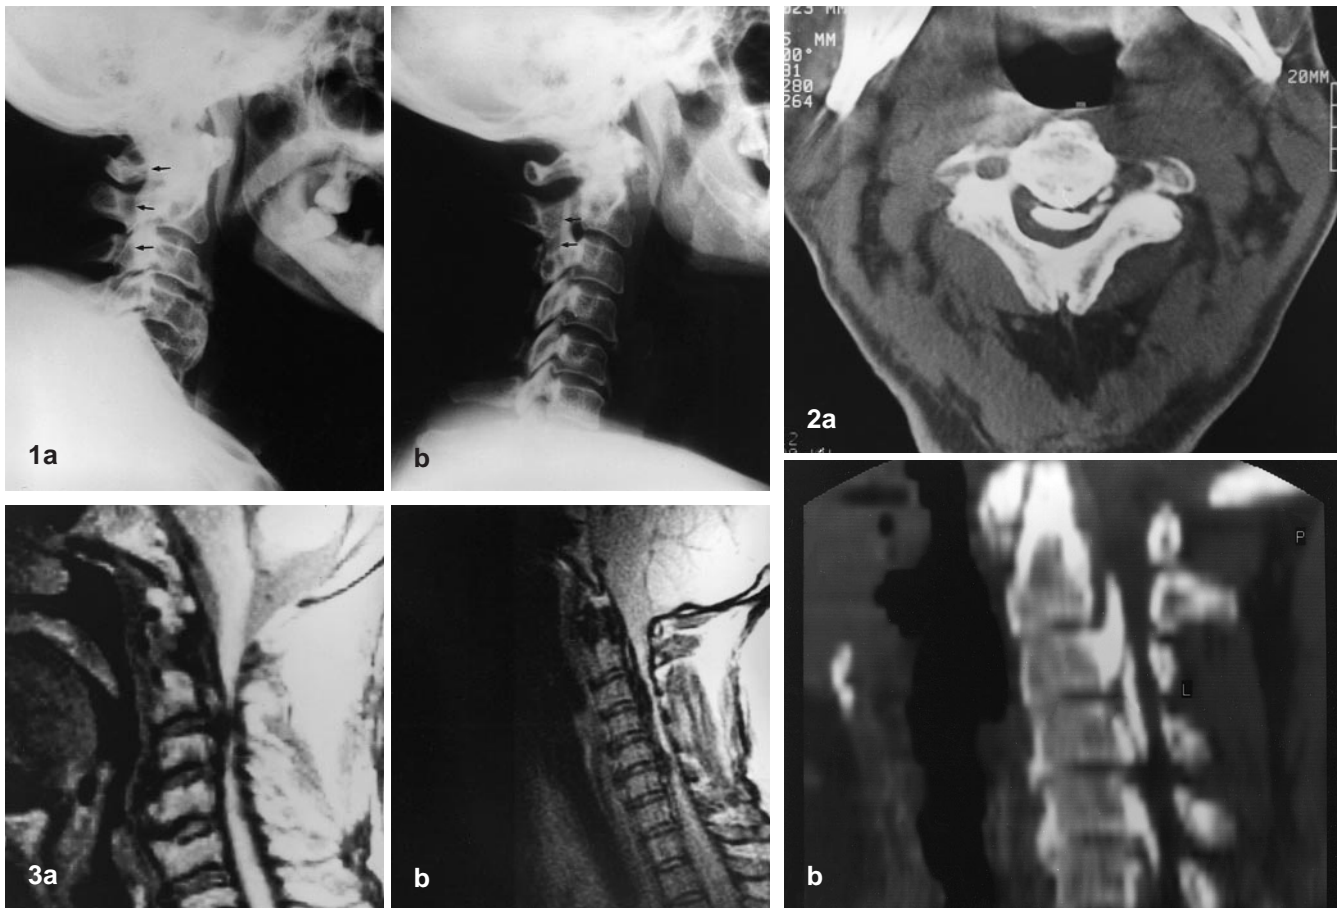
a, b Plain radiographs of the cervical spine in lateral view. a Case 1: thick retrovertebral longitudinal opacity extending from C1 to C4, more marked at level of C2 and C3. b Case 3: linear retrovertebral opacity, more evident between C2 and C4
